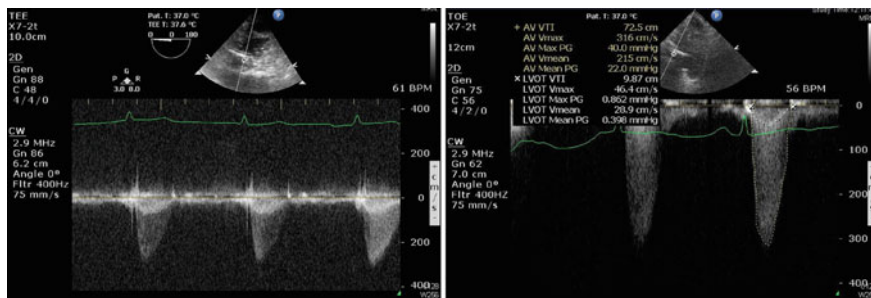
a CW Doppler trace through aortic valve. Note the double shadow signifying the acceleration past the AV. b CW Doppler double shadow being analysed using VTI which will be used to calculate the valve area
